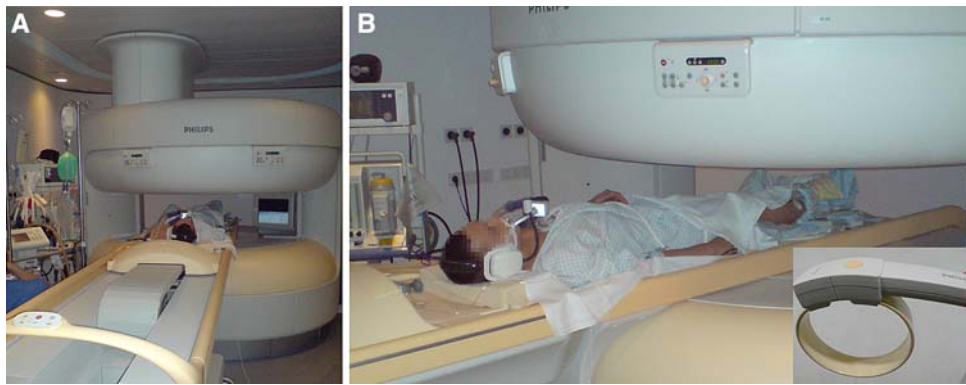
(A) View of patient positioned in the open high-field MRI (1.0 T, Panorama HFO, Philips) for real-time MR-guided laser ablation of an osteoid osteoma of the right fibula. Needle insertion and laser release during intervention are visible on an in-room monitor beside
